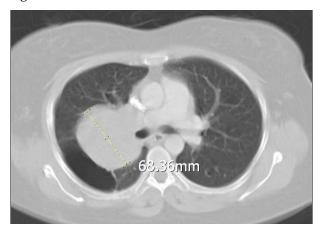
CT scan of the chest showing a large right pulmonary mass.
